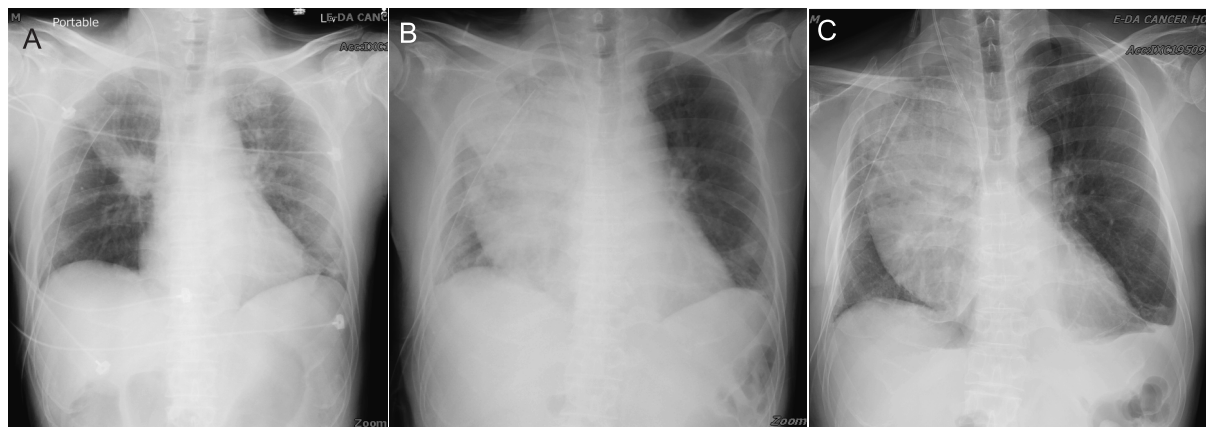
(A) Routine post-operative chest radiography showed patch opacity in the right upper lung field and increased infiltration in the left lower lung, (B) The CXR showed a rapidly progressed right lung consolidation and an indwelling right chest tube on postoperative Day 3, (C) Ill-defined opacities over the right lung on postoperative Day 5.
